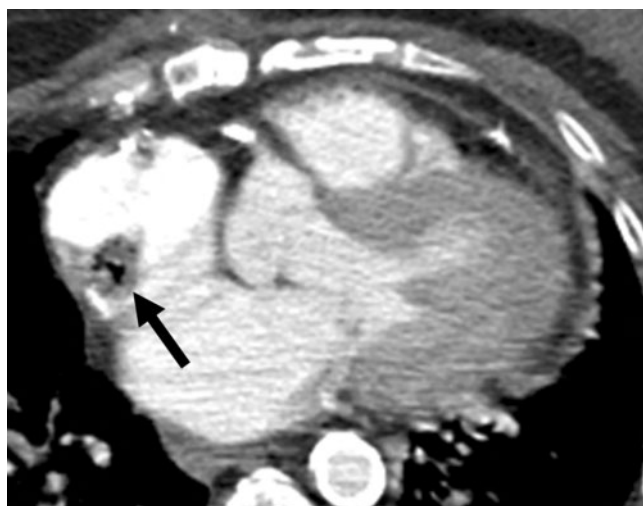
Axial CT image showing an air-containing filling defect attached to the free wall of the right atrium (arrow). The appearance is pathognomonic of a right atrial thrombus infected with a gas-forming organism.
